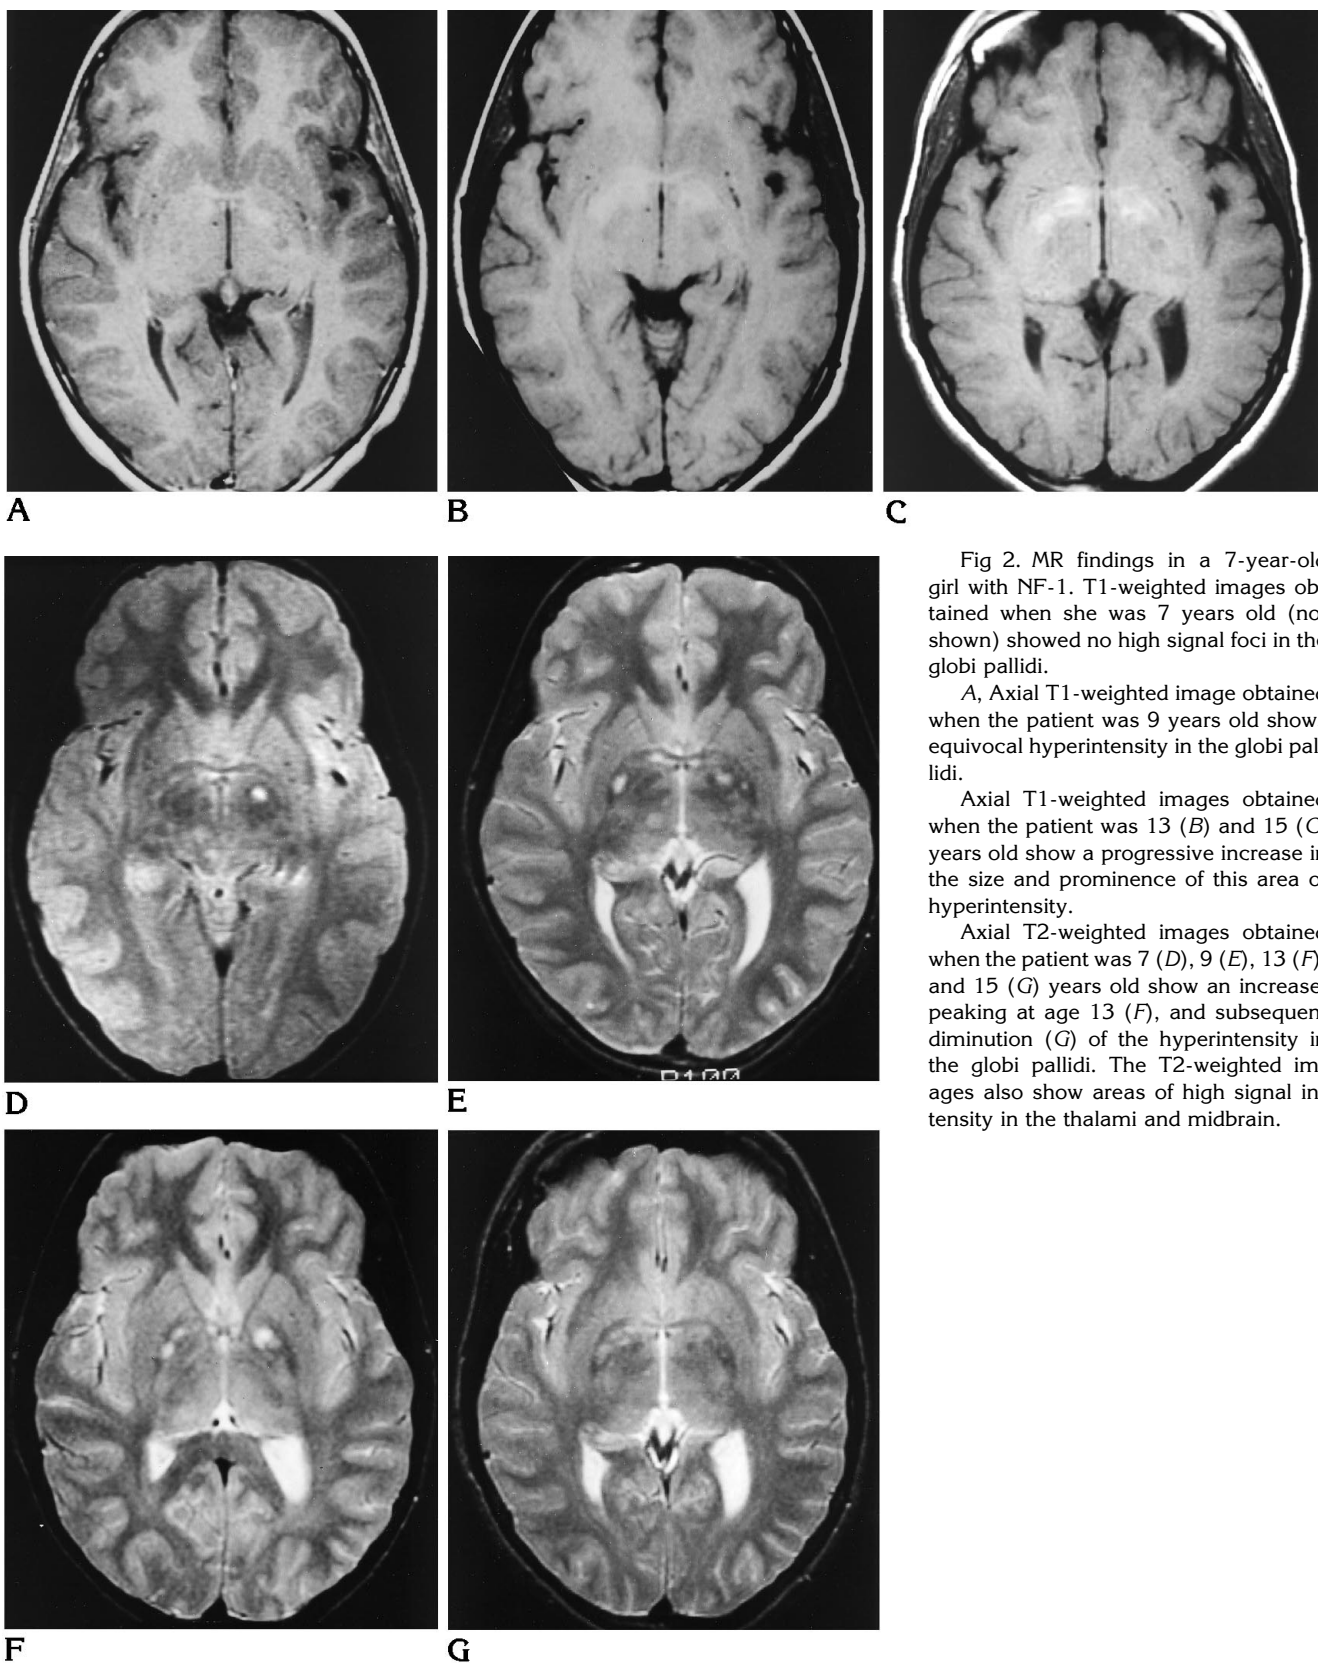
MR findings in a 7-year-old girl with NF-1. T1-weighted images obtained when she was 7 years old (not shown) showed no high signal foci in the globi pallidi.
